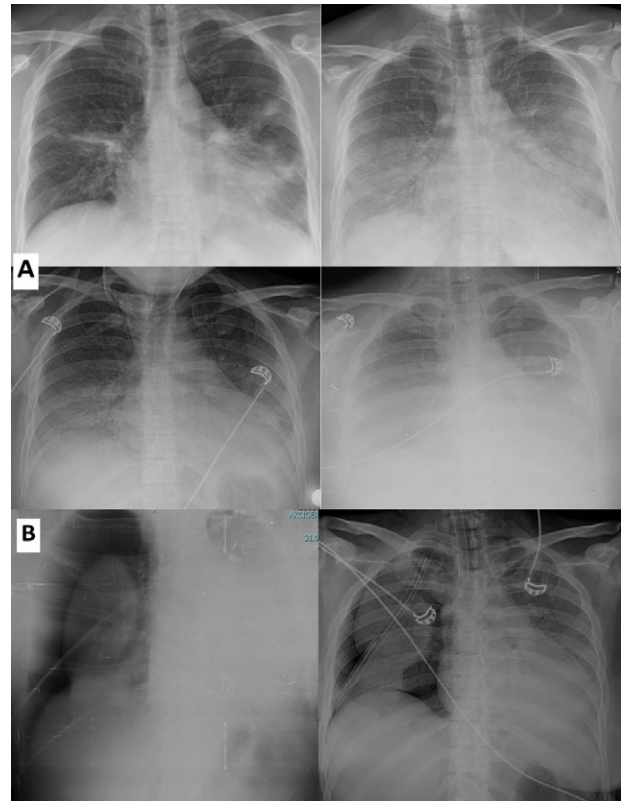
Chest X-ray images are showing the early, progressive and severe phases of COVID 19 in a 33 years-old female patient within two weeks (4A). Pneumothorax was noted and there is no expansion despite the chest tube insertion due to loss of elastic recoil of pulmonary parenchyma is shown in Figure 4B. And, she died from pneumothorax and respiratory failure.
